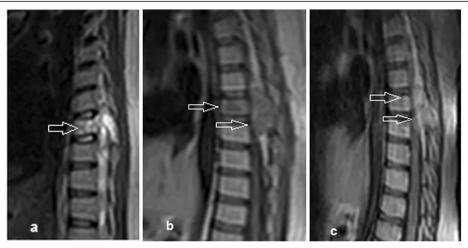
MRI demonstrates a D7 vertebra body and right lamina osseous lesion with soft tissue component compressing the dorsal spinal cord, eliciting high signal in a sagittal T2W, isointense signal in b sagittal T1W, and rather homogenous enhancement in c post-contrast T1W
